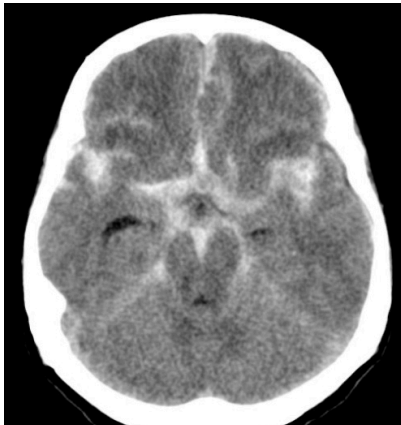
Computed tomography (CT) scan showing a typical finding of aneurysmal subarachnoid hemorrhage. *Source: Radiopaedia (www.radiopaedia.org)*
